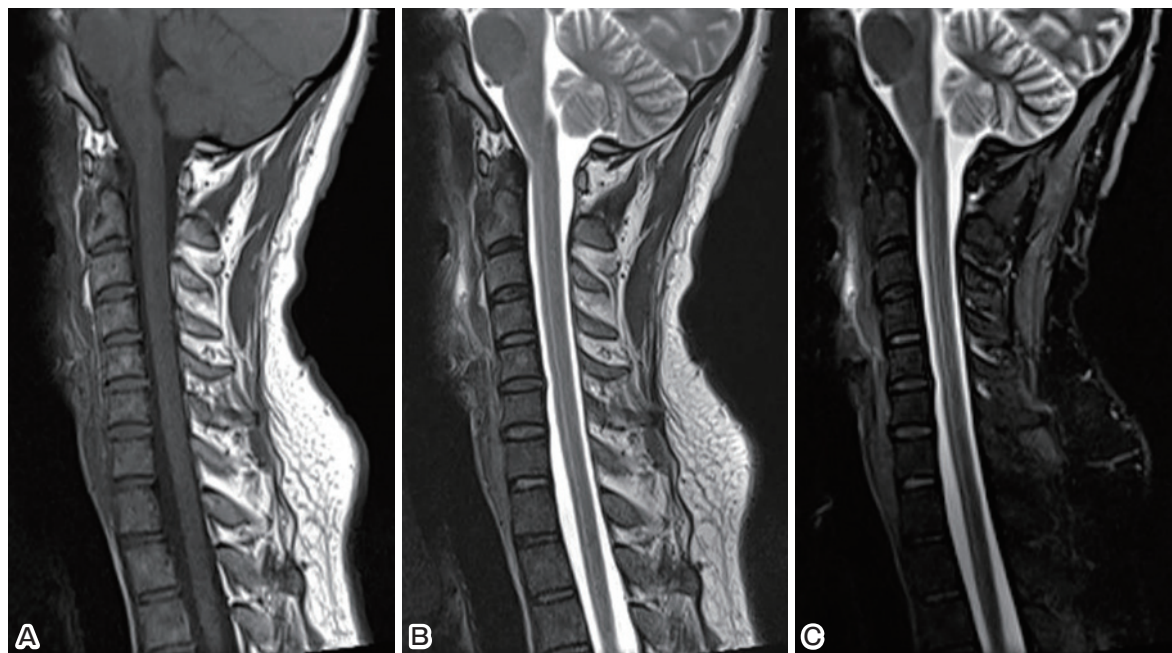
Postmortem MRI of the neck: sagittal image of T₁WI (A), T₂WI (B), and short-tau inversion recovery (C) showing no evidence of spinal cord injury or soft tissue damage.
